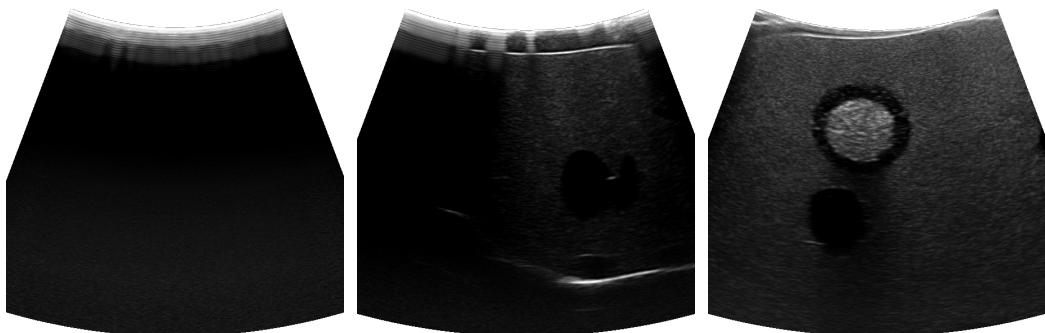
Three ultrasound images from left to right: No contact with the liver, difficult to decide (In this case it would be contact because the middle part of the image shows contact), contact with the liver
